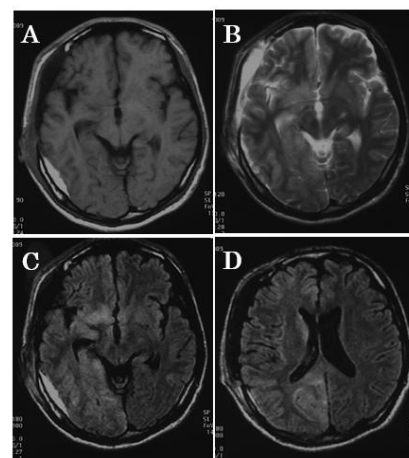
Case 2. Head MRI (axial image). A: (FLAIR). B: (T2WI). MRI shows the remaining thin right subdural hematoma. C, D: (DWI) MRI shows high-intensity change in the right frontal lobe, temporal lobe, occipital lobe, and corona radiata.
